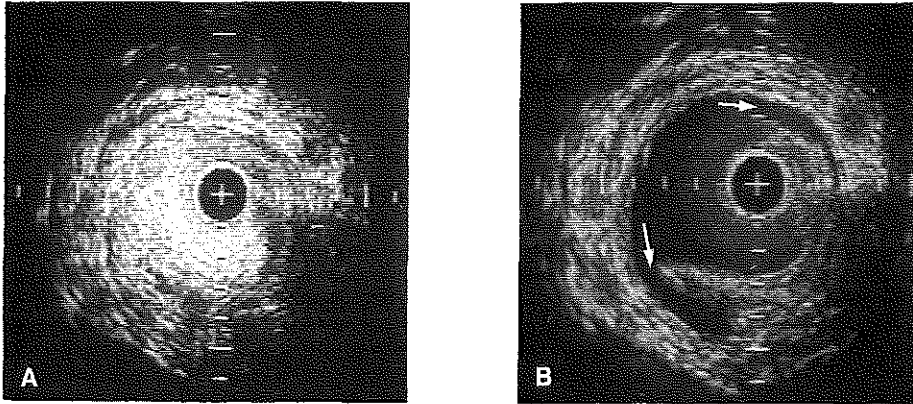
Intravascular ultrasound cross-sections of the superficial femoral artery showing the advantage of saline injection for off-line analysis of still-frames. A, Echogenicity of blood hampers delineation of the lumen contour. B, Following saline injection plaque dissection (arrow) became evident on the still-frame. Calibration 1 mm.
